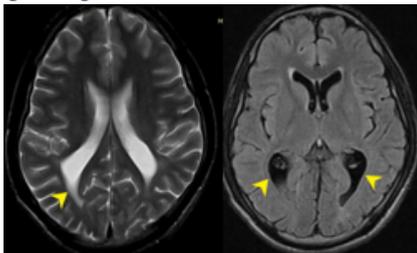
Axial T2 and FLAIR images in 21yr old male presenting with mild cognitive disability shows periventricular T2 hyperintense signal and prominence of bilateral occipital horns.
